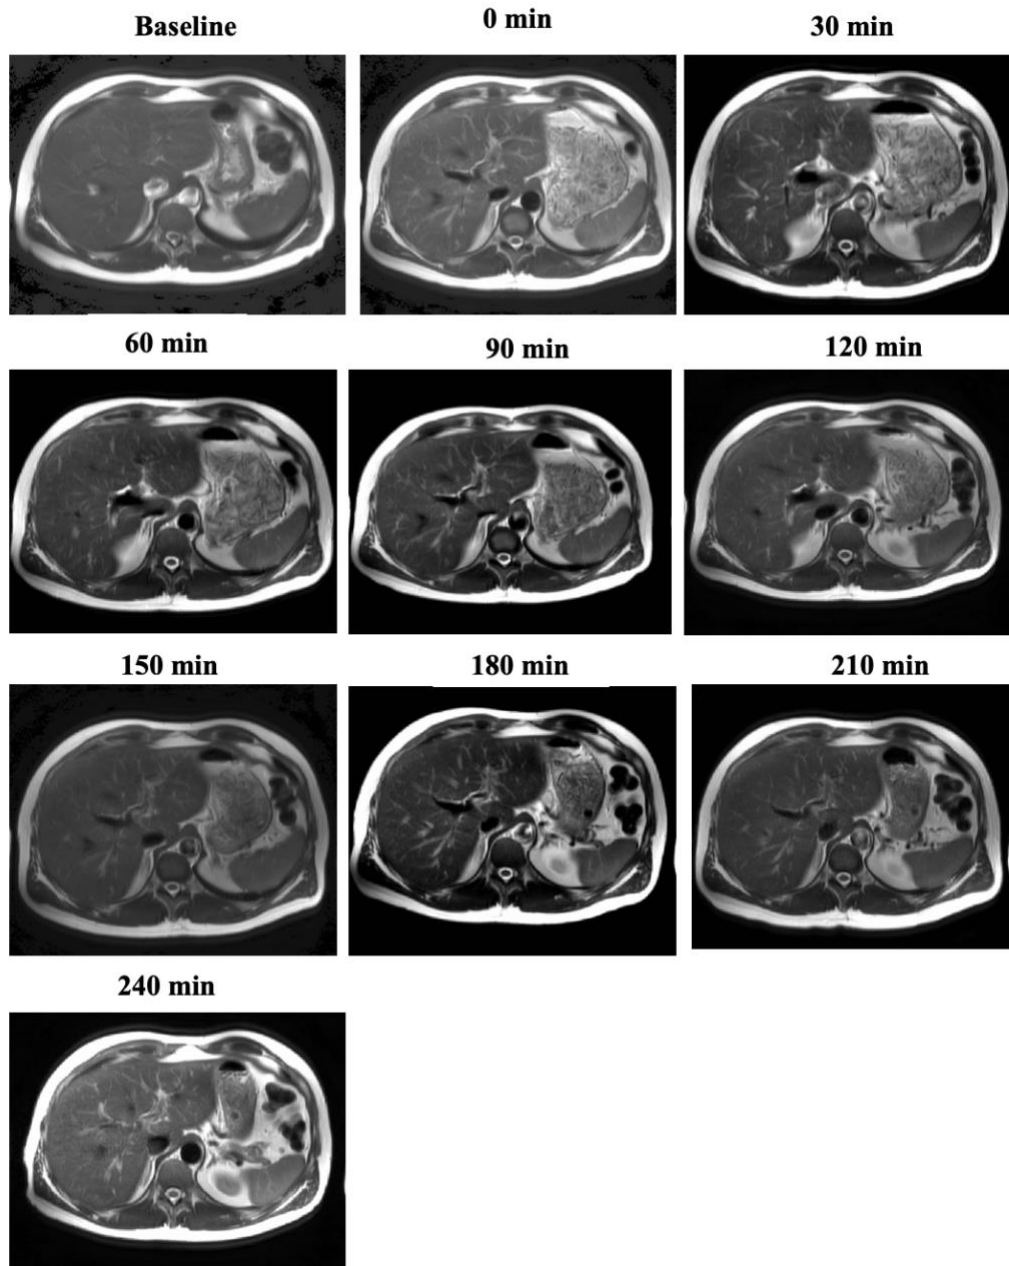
MRI images of stomach of a normal-weight participant at fasting baseline and after consumption of the test meal.
